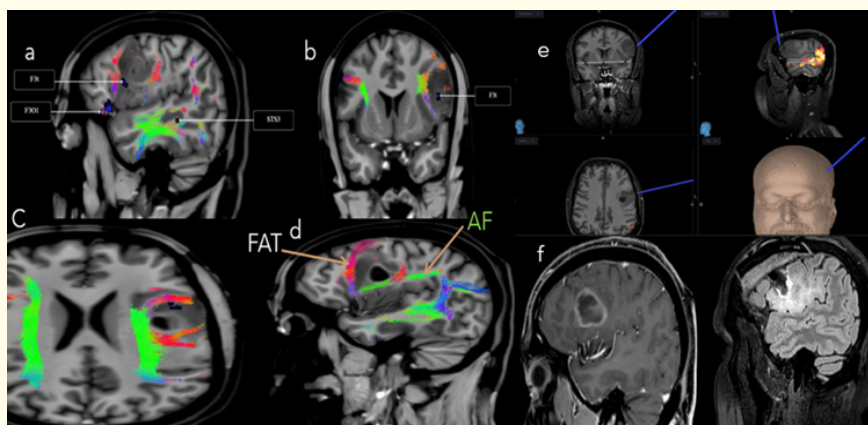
a,b- showing language parcellations, c,d- showing FAT , AF and IFOF, e, neuronavigation integrated functional networks, trajectory showing away from parcellation, F- Pre and post operative MRI scans showing complete tumor excision.
